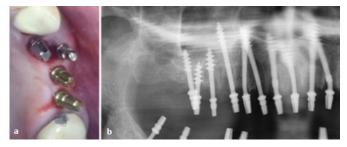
a. Application of two corticobasal implants buccally and lingually in the maxillary first premolar tooth region b. Radiographic image after application of 2 separate implants to the roots in the maxillary molar tooth region
